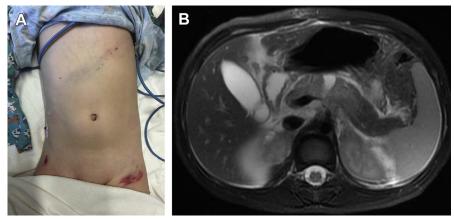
Seat belt injuries. A 3-year-old restrained back seat passenger in a booster seat with lap and shoulder restraints presented with upper and pelvic bruising from the restraining belts. The lower abrasions over the anterior superior iliac spines demonstrate appropriate positioning and did not contribute to injury. The shoulder belt was too low over the upper abdomen, resulting in a pancreatic transection. (*A*) Clinical photo. (*B*) MRI demonstrating pancreatic laceration.
